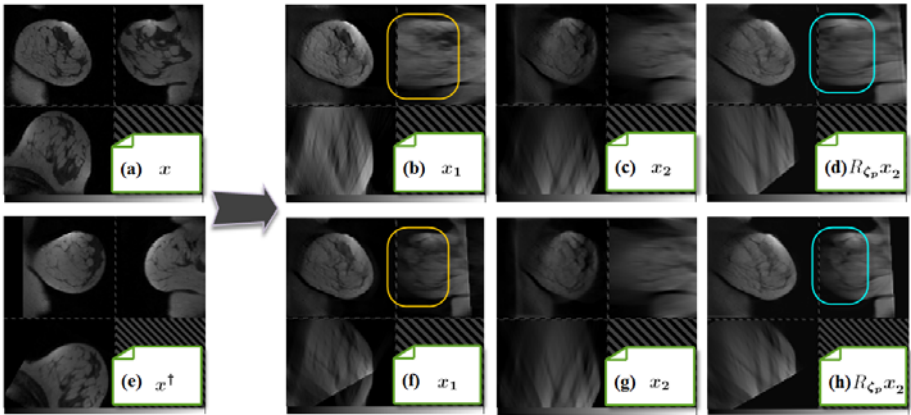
As Fig. 1 but for a 3D uncompressed breast MR image
